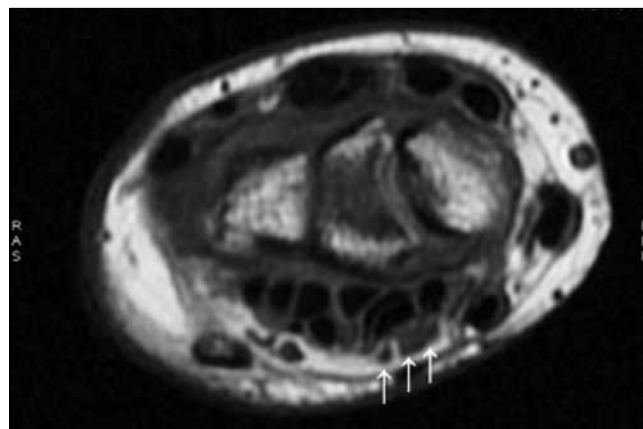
Axial T1-weighted MR image of the left wrist, three branches of the median nerve at the level of the radiocarpal joint (white arrows).
